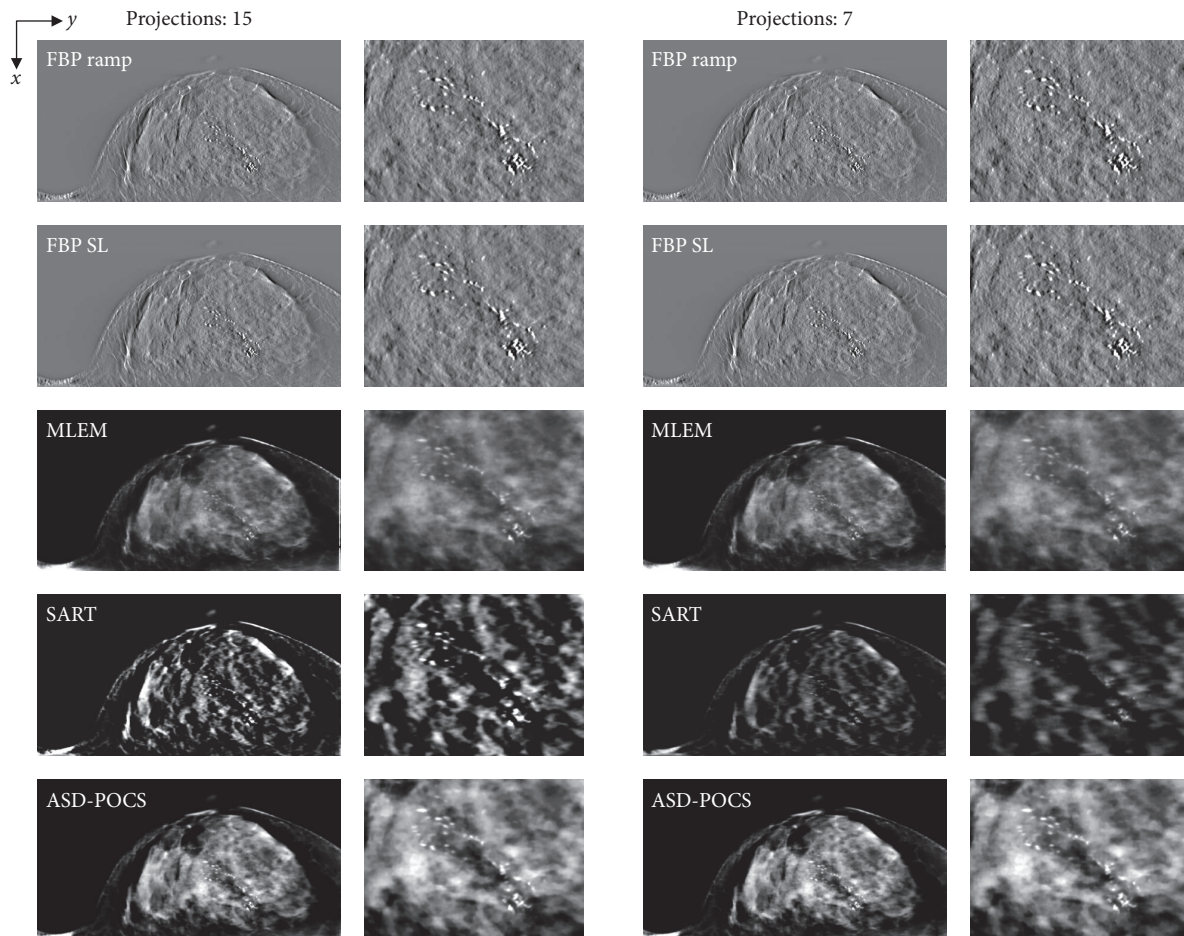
Case 1. Comparisons between images obtained at different projection numbers (normal: 15, half: seven) using each tomosynthesis reconstruction algorithm in the in-focus plane. The X-ray source was moved horizontally along the image. Zoomed images depict the lesion areas. For each corresponding set, IR (MLEM, SART, and ASD-POCS) images are displayed at the same window width and level, whereas the FBP images have a larger window widths because the backgrounds are less flattened and the gray levels in larger areas would be out of scale in narrower windows.
